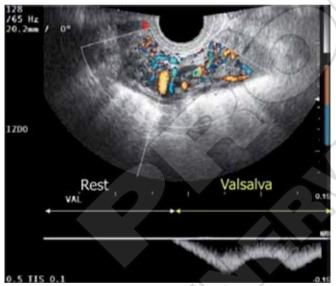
Transvaginal color Doppler ultrasonography in a patient with isolated reflux without LRV or iliac vein compression. Top: Pelvic varices, whose size can be measured. Bottom: There is absence of base-line flow. An oscillatory reflux is identified during a Valsalva manoeuver.
